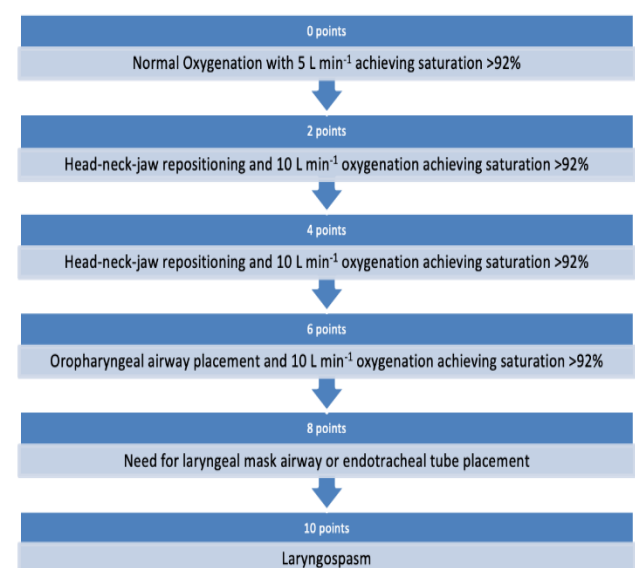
Airway safety during the MRI procedure
